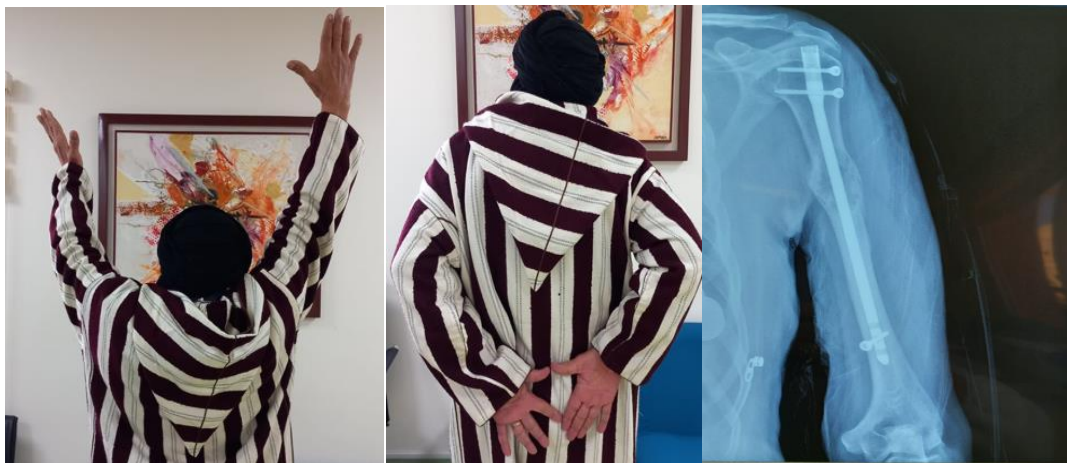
Three-month postoperative radiograph and clinical photographs showing satisfactory fracture healing following intramedullary nailing, with restoration of left upper limb function
